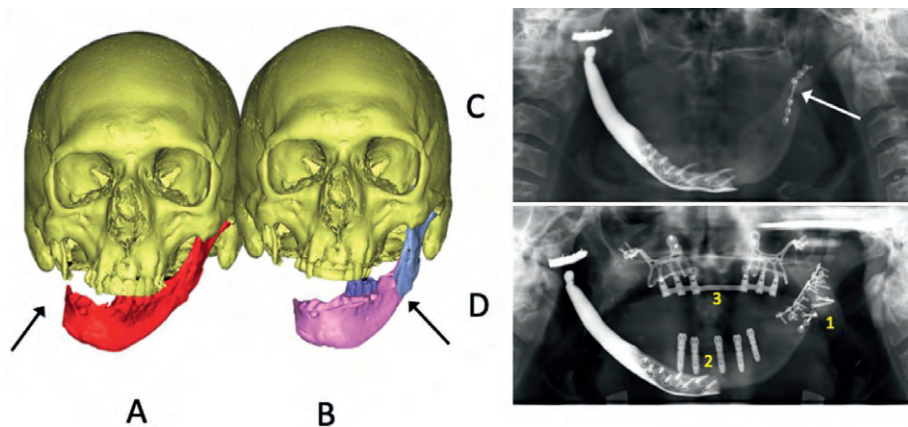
Case # 3. (A) Surface tessellation language render with the arrow indicating the defect. (B) Surface tessellation language render with planned rotational repositioning of the mandible. The arrow indicates the sagittal split osteotomy contralateral to the extended temporomandibular joint replacement. (C) Orthopantomogram demonstrating an osteosynthesis plate fracture (arrow). (D) Orthopantomogram demonstrating extensive osteosynthesis and iliac bone grafting (1), root-shaped dental implants (2), and an additively manufactured subperiosteal jaw implant (3) one has the impression that mandible was splitted at a higher position than indicated in B. This is due to the fact that the proximal segment rotated antero cranially because of the malunion and because of the projective geometry of orthopantomogram technology
